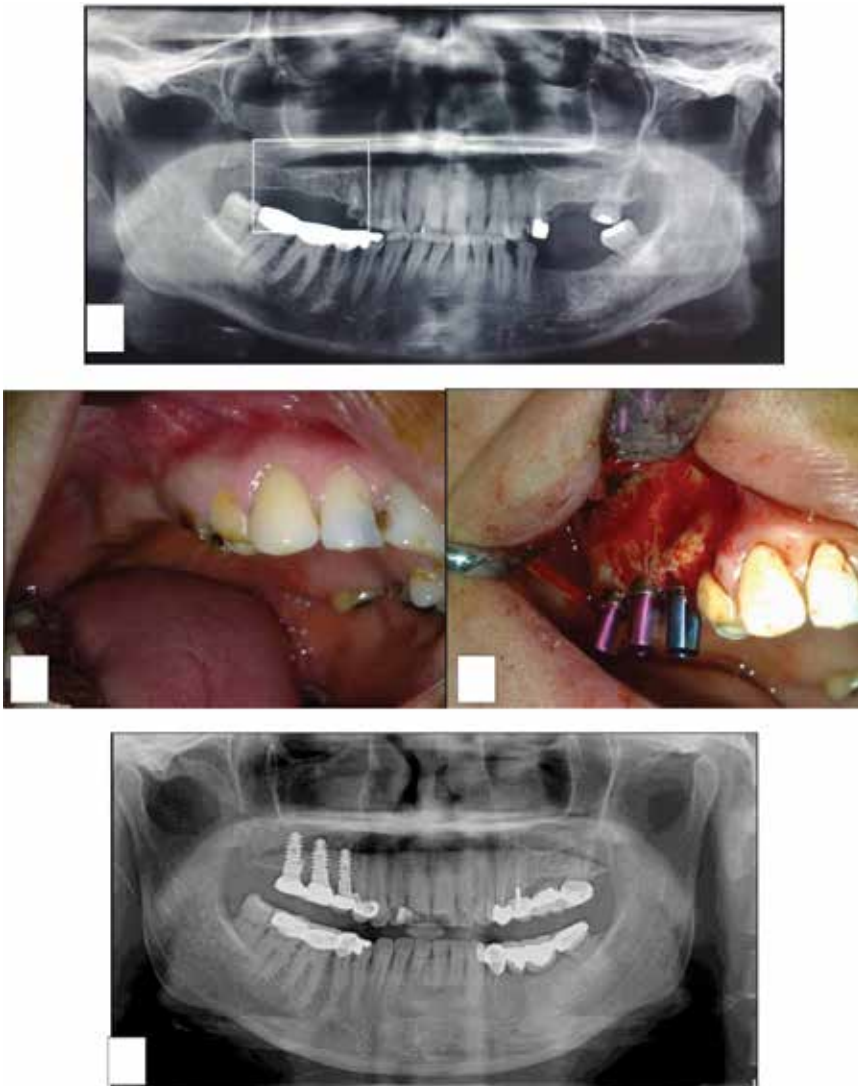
Augmentation of the atrophic posterior maxilla (a) The insufficient bone volume at the right posterior maxilla. (b) Intraoral clinical view (c) Sinus bone grafting with xenograft (Bioss®, Geistlich Germany). Implants were inserted simultaneously with sinus membrane elevation. (d) Panoramic radiograph after 1 year.
